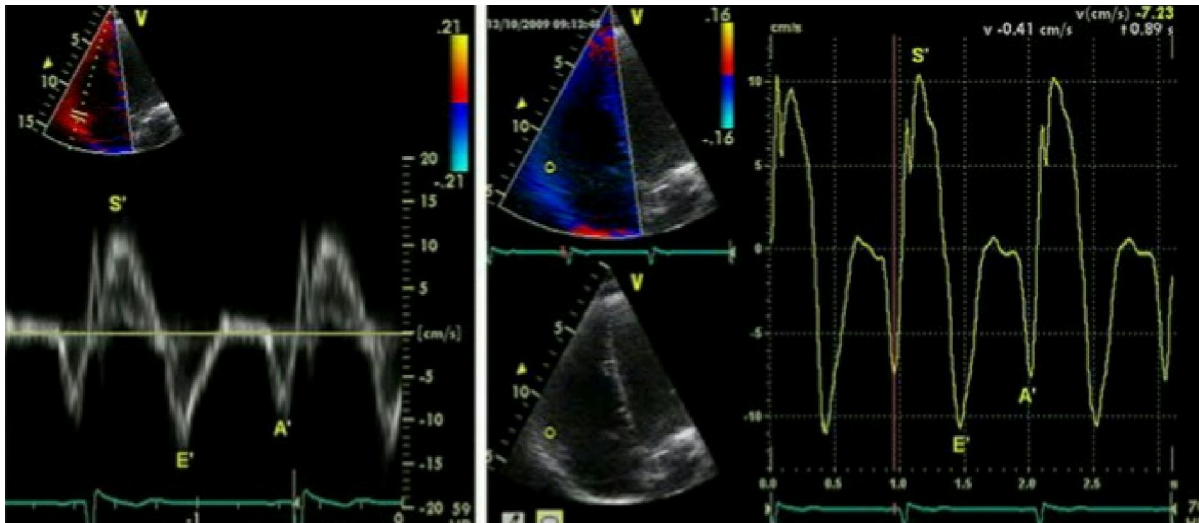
Tissue doppler of the tricuspid annulus in a patient with normal right systolic function (left) pulsed and (right) color coded offline analysis
